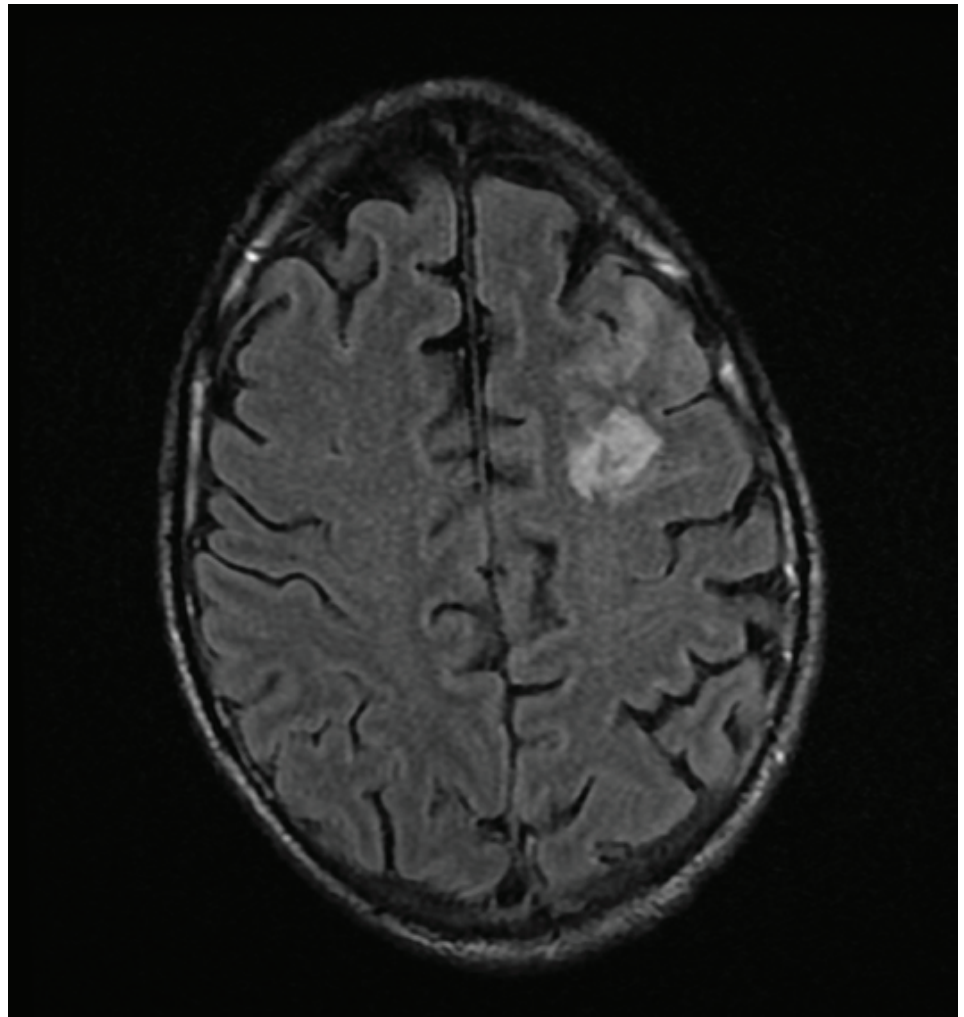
MRI Brain showing acute to subacute infarct in the left front lobe consistent with embolic phenomenon
